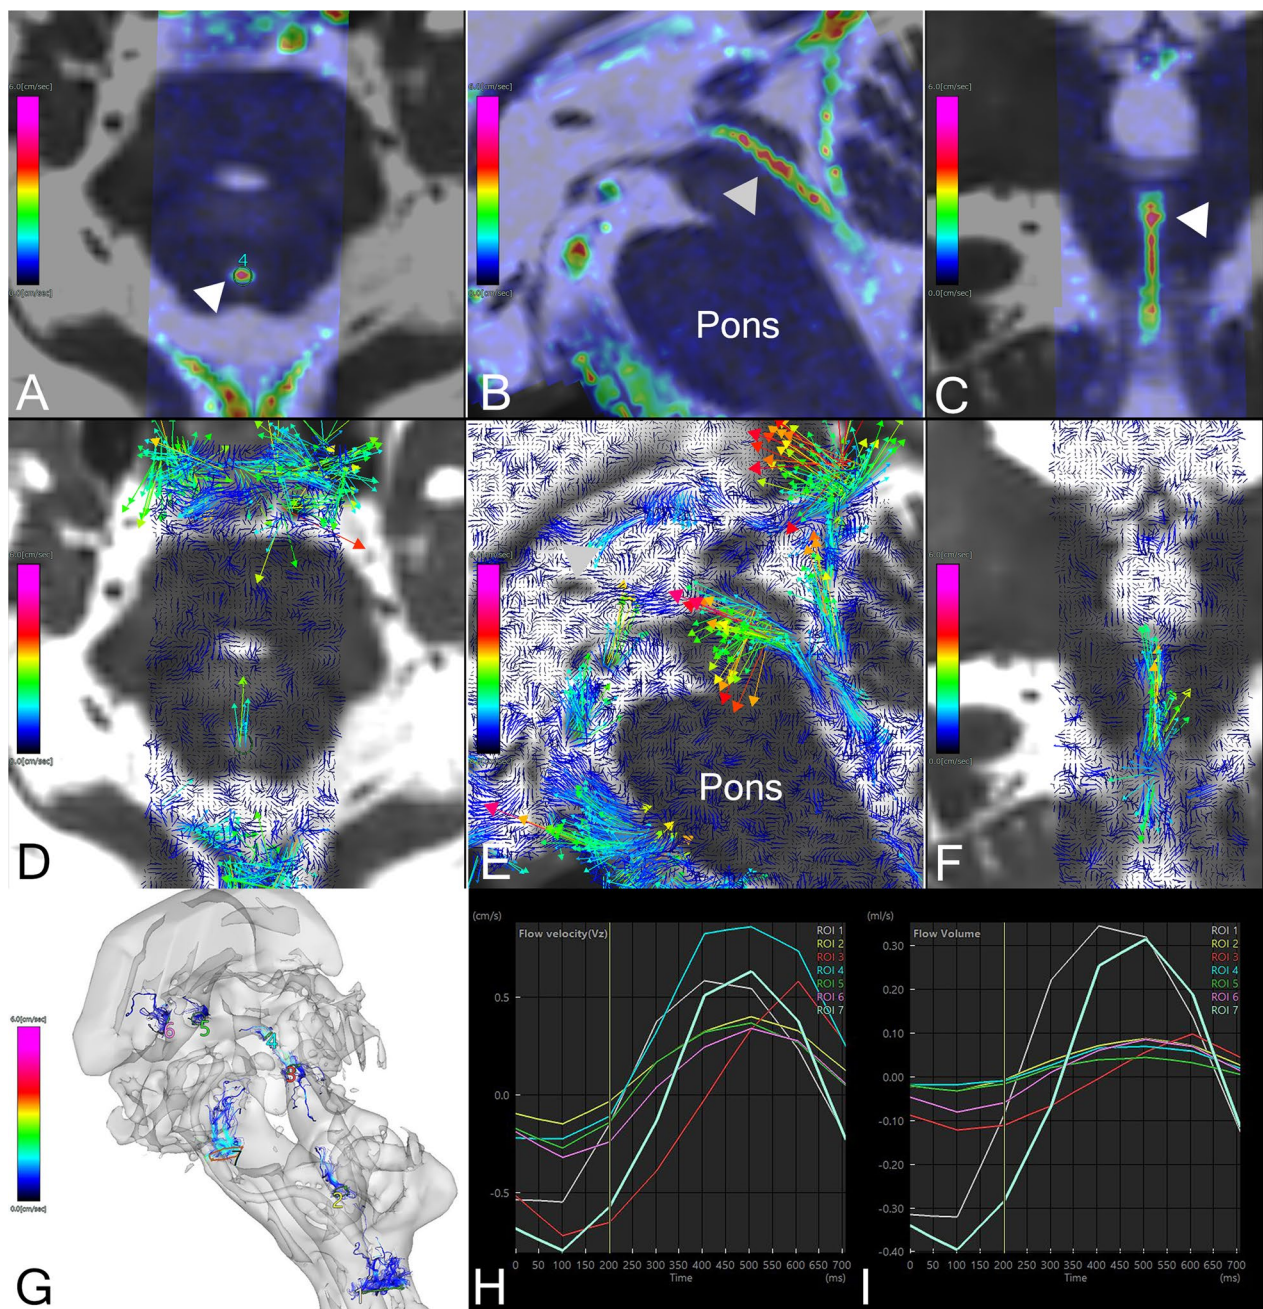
Four-dimensional flow magnetic resonance imaging. The axial (A) sagittal (B) and coronal (C) colormap views of 4D flow MRI analysis show the velocity magnitude of CSF movements around the cerebral aqueduct (white arrowheads) in a representative patient with Hakim’s disease (73 years old, female). The colored area indicates the area where the 3D flow velocity (cm/s) was measured on 4D flow MRI, and the color bar indicates the magnitude of the 3D velocity of reciprocating CSF movements: red for fast and blue for slow. The 2D sagittal views of flow vectors (D–F) show the CSF movements with direction and velocity. The color and size of arrows indicate the velocity magnitude. The 3D view of streamlines (G) shows the CSF movements through seven ROIs during a heartbeat (a movie of the streamlines was attached to the supplemental materials). The line graph H shows the flow velocity and the line graph I shows the flow volume at seven ROIs. The ROIs were manually drawn at seven points, including the dorsal aspects of the foramen magnum (ROI1), foramen of Magendie (ROI2), lower (ROI3) and upper (ROI4) parts of the cerebral aqueduct, left (ROI5) and right (ROI6) foramina of Monro, and prepontine cistern (ROI7). The line graphs show the temporal changes of flow velocity (H) and flow volume (I) at these ROIs during the cardiac cycle
